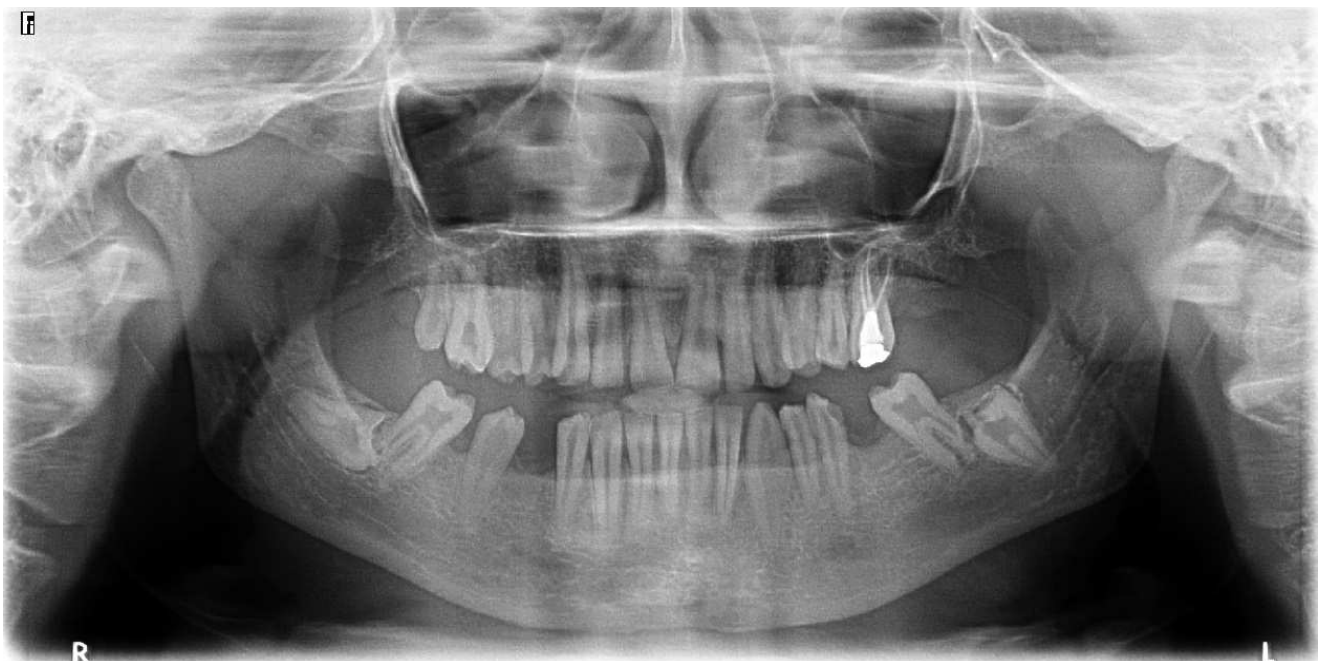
Patient's panoramic radiography.
